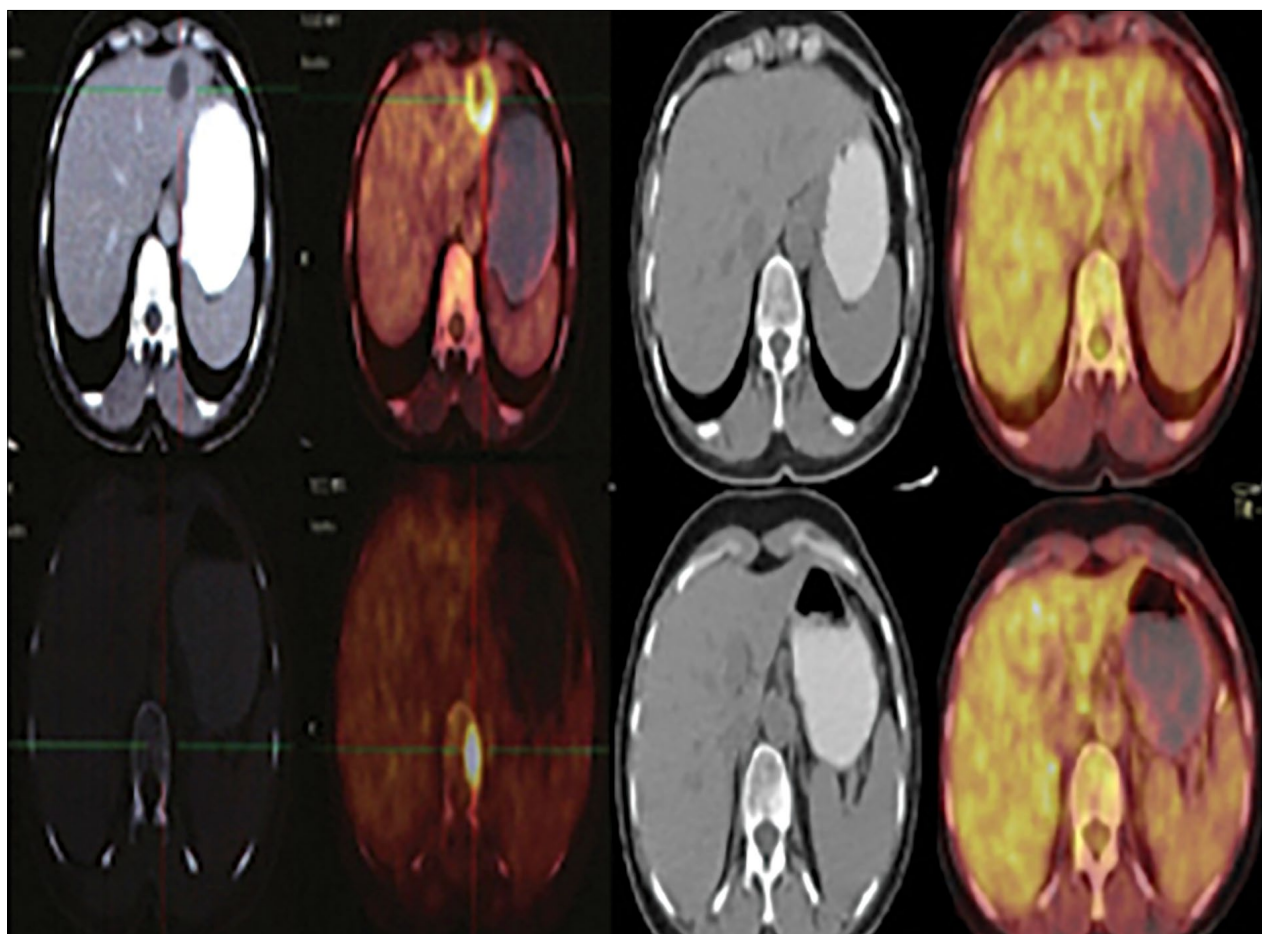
(a) CECT image and (b) PET-CT image at the time of recurrence (c) PET-CT image after SBRT treatment and after 24 months of treatment.
